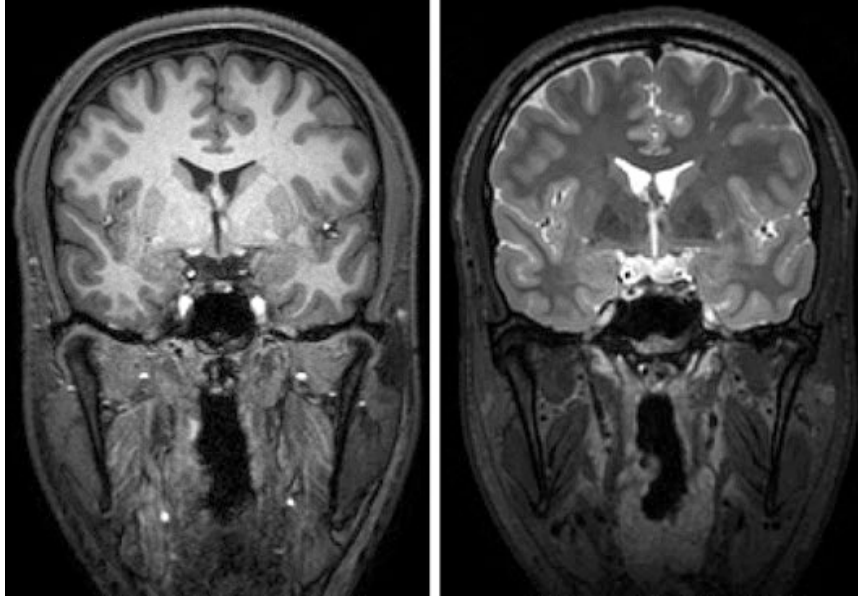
Example of high-quality T1- and T2-weighted scans likely to work well with SimNIBS. Note that in the T1-weighted scan, the skull appears dark due to the fat suppression
